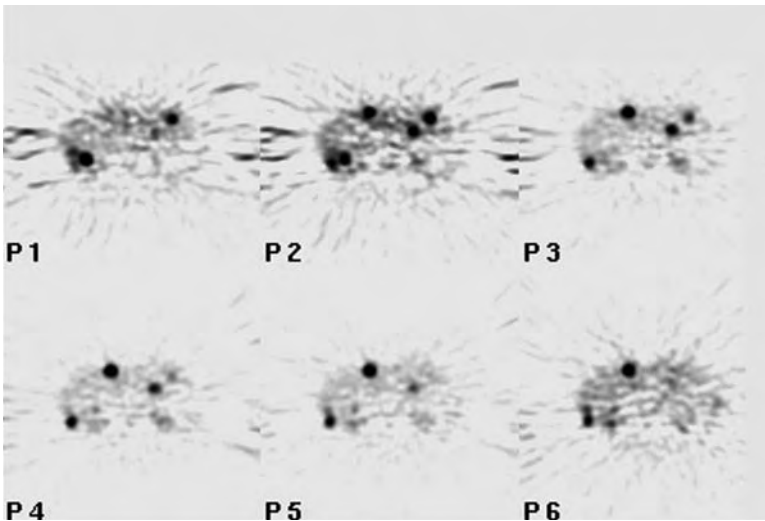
Re-staging of breast cancer. Extensive liver metastasis was found in this 49-year-old white female. CT revealed two metastases in the left liver lobe. Six consecutive slices of 10 mm, P1-P6 (ECAT ART PET system)
